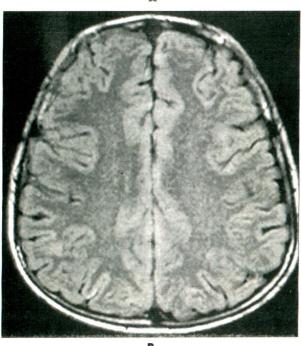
Initial MR study, axial FLAIR (TR: 7000, TE: 110, TI:2000) image shows bilateral symmetric high signal intensities in the frontal and parietal lobes (A). Axial FLAIR image obtained at 5-week follow-up demonstrates complete resolution of the areas of high signal intensity (B).
